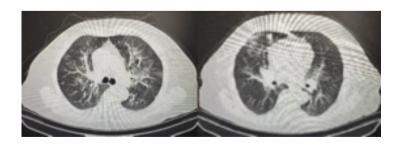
Thorax CT images of the patient; mosaic attenuation, linear atelectasis, focal ground glass areas
